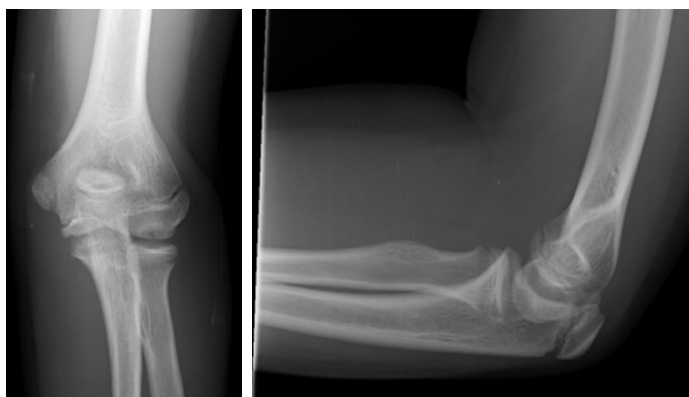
AP and lateral radiographs of the elbow demonstrating areas of capitellar lucency consistent with osteochondritis dissecans
